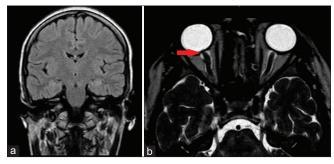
(a) T2 fluid-attenuated inversion recovery (FLAIR) image showing no periventricular plaques suggesting no changes of multiple sclerosis. (b) T2 DRIVE image showing retrobulbar thickening and tortuosity of the optic nerve, which is more on the right side (red arrow)
